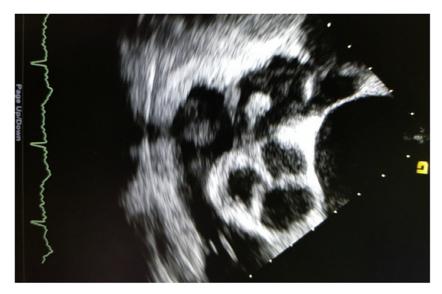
Two-dimensional transesophageal echocardiography of papillary fibroelastoma.
